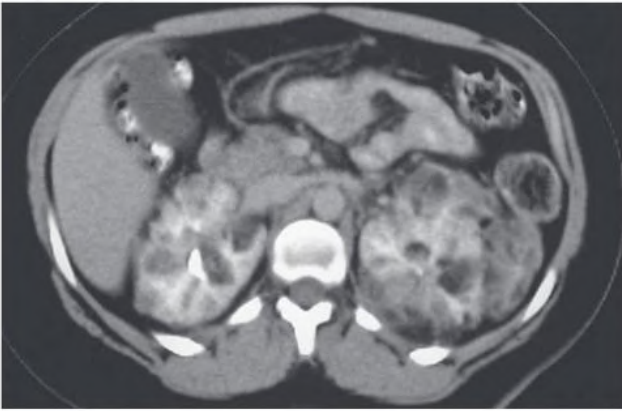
Contrast-enhanced computed tomography showing bilateral angiomyolipomas associated with tuberous sclerosis complex.
